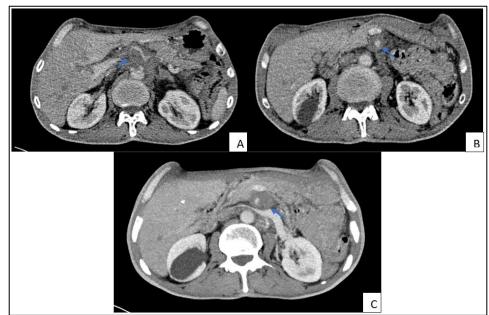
Axial images of abdominal CT with contrast showing a hypodense soft tissue mass with irregular margins (arrow), circling the coeliac trunk (A) and superior mesenteric artery(B and C)
